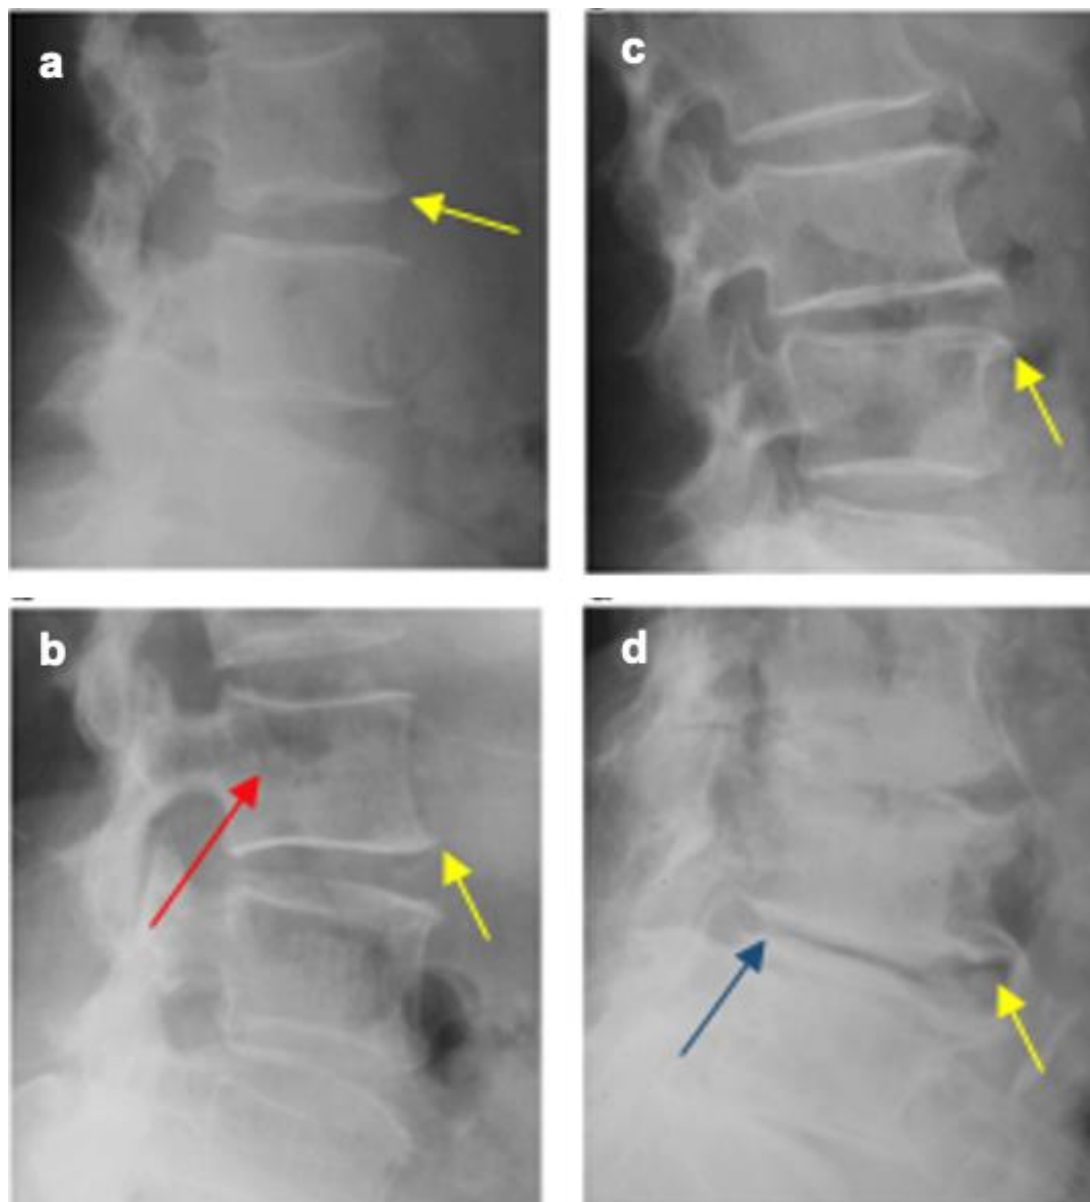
Interpretation of the Kellgren-Lawrence grading on X-ray. (a) KL-1: no osteophyte visible; (b) KL-2: osteophyte visible; (c) KL-3: osteophyte and narrowing of the intervertebral disc (blue arrow) visible; (d) KL-4: prominent osteophyte, associated with narrowed intervertebral disc, and sclerotic (red arrow). Yellow arrows indicate osteophytes (Tsujimoto et al., 2016).
